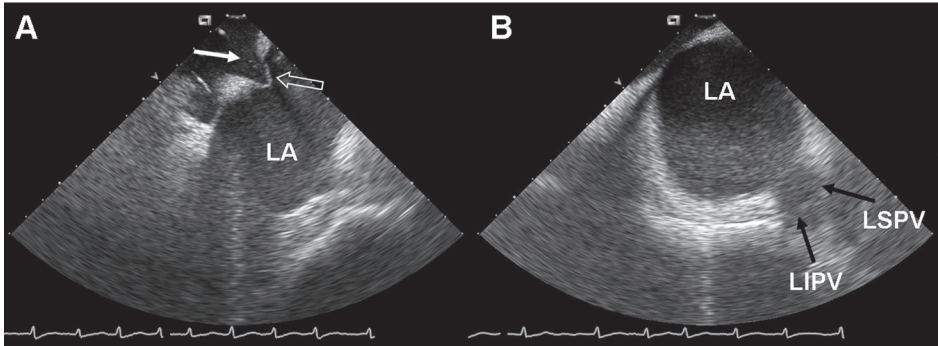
Intracardiac echocardiography during a catheter ablation procedure for AF. Panel A: The transseptal puncture is guided by ICE to gain access to the LA. The white arrow indicates the transseptal sheath aimed at the fossa ovalis, which is the preferred site for the transseptal puncture. The 'tenting' of the septum (open arrow) indicates stable contact of the sheath with the fossa ovalis. Panel B: The anatomy of the pulmonary veins can be assessed with ICE during the ablation procedure. In this patient, the left inferior pulmonary vein (LIPV) and the left superior pulmonary vein (LSPV) have a single insertion in the LA, a so-called 'common ostium' of the left-sided pulmonary veins.
